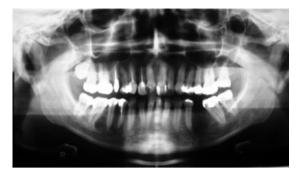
Panoramic radiograph showing the lesion between the right second mandibular premolar and first molar.
